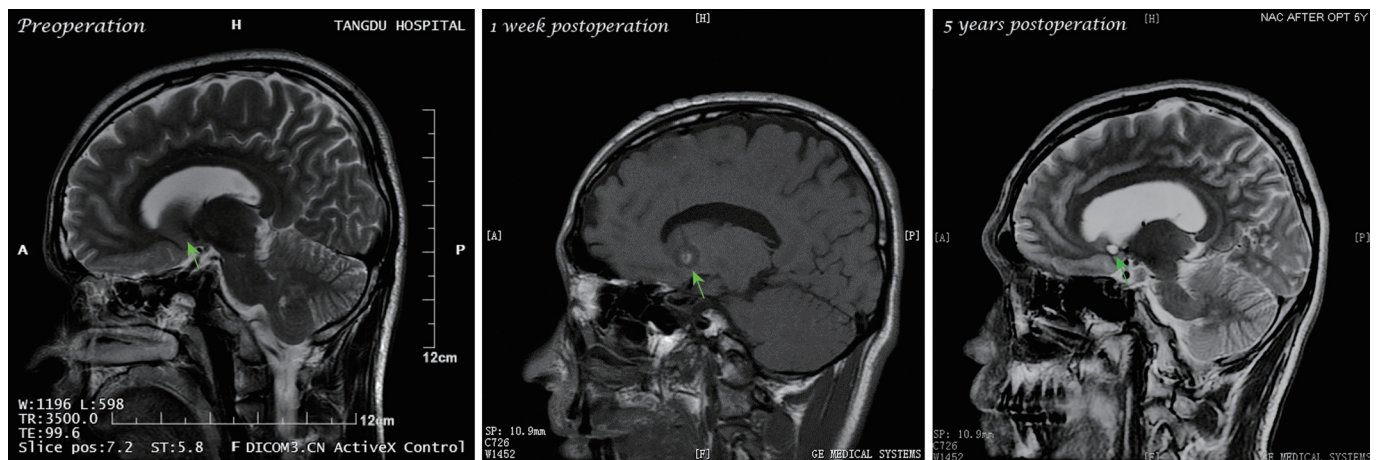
The sagittal view MRI of the surgery opiates-dependent patients. The place marked by the arrow is the proximal NAC.
